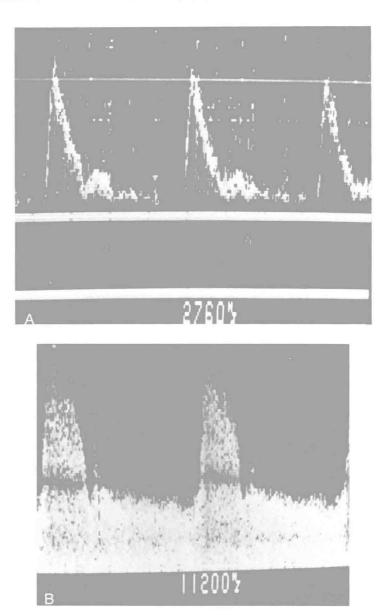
(A) Normal Doppler velocity pattern from the aorta. This temporal waveform display is the Fourier transform of the signal and shows that the peak systolic velocity, which occurs early in systole, is 2760 Hz. There is relatively little diastolic velocity. The waveform is clean and shows very little spread of frequencies indicating lack of substantial turbulence. The amplitude of the frequencies are represented as gray-scale intensity. (B) Fourier-transformed Doppler signal from a stenotic vessel shows that the systolic portion is composed of a spread of frequencies, indicating turbulence. The peak velocity is increased to greater than 11,000 Hz because of the jet effect at the stenotic orifice and there is a substantial amount of residual velocity during diastole because of the stenosis.
